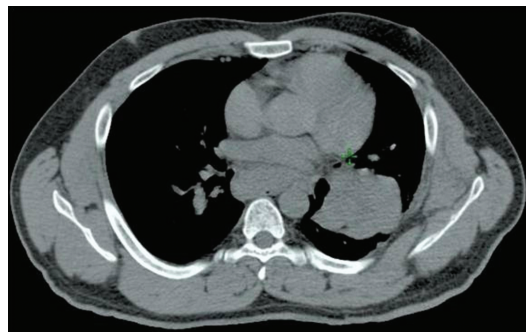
Chest CT scan showing a left perihilar mass.
